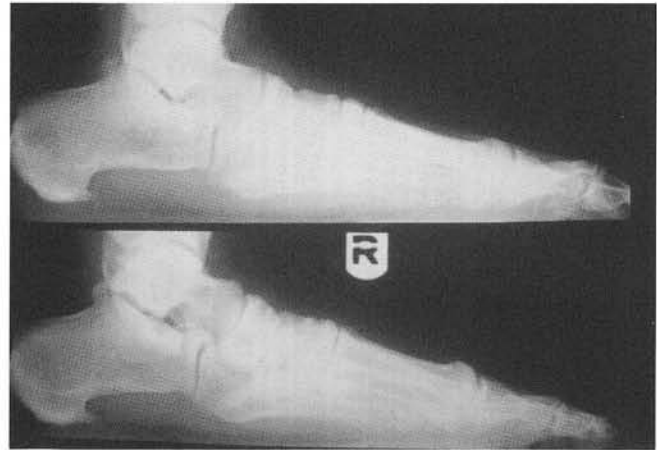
Preoperative lateral weightbearing radiograph
